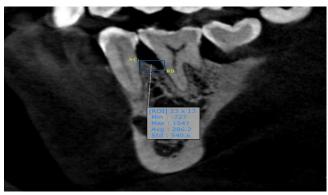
cone beam computed tomography at baseline – sagittal view -bone density by ROI.
